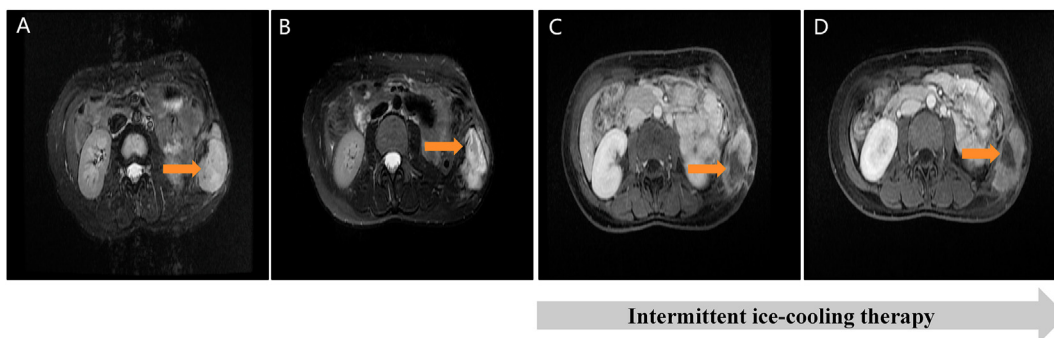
Therapeutic effect of HIFU treatment on tumor detected by MRI. (A) Before the 1st HIFU treatment. (B) After the 1st HIFU treatment. (C) After the 3rd HIFU treatment. (D) After the 6th HIFU treatment. Red arrows indicated the lesion. HIFU = high-intensity focused ultrasound. MRI = magnetic resonance imaging.
